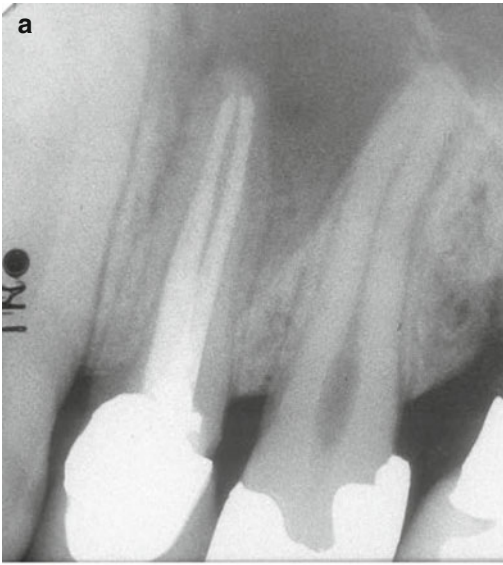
(a–d) Patient history revealed that 5 years prior to arriving at the dental office, root canal therapy was performed on the maxillary first premolar with an amalgam dowel and PFM crown. The patient’s chief complaint was tenderness on biting and a “loose tooth.” The patient also experienced two episodes of swelling in the area over the past 3 years. Clinical examination revealed slight mobility, sensitivity to percussion, and a 7 mm probing defect on the midbuccal area. The first periapical radiograph revealed a well-obtured root canal and large “halo” radiolucency (a). An additional radiograph with a slight change in angulation showed (b) this tooth to be a bifurcated maxillary premolar. When a VRF is suspected it is highly recommended to take two periapical radiographs from different angulations. There was no sinus tract in the attached gingivae, and a definitive diagnosis of a VRF tooth could not be done. The patient declined a surgical flap procedure for final diagnosis and treatment. The tooth was extracted (c). The typical depression on the bifurcation aspect of the buccal root with the longitudinal fracture along the depression can be seen in this image following some shaving of the palatal root (*black arrow*). In one of the cross sections done (d), complete VRF from one side of the root to the other can be seen in both roots. The typical depression in the buccal root can also be seen
